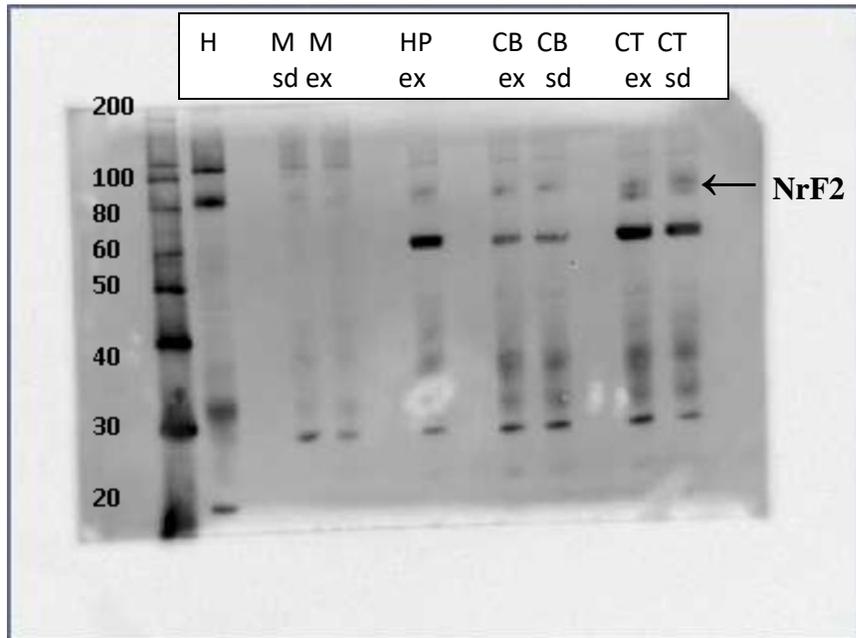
Identification of Nrf2 at 80kda Across Multiple Cell Types. H=Heart, M=Muscle, HP=Hippocampus, CB=Cerebellum, CT=Cerebral Cortex, sd=Sedentary, ex=Exercise Trained.
